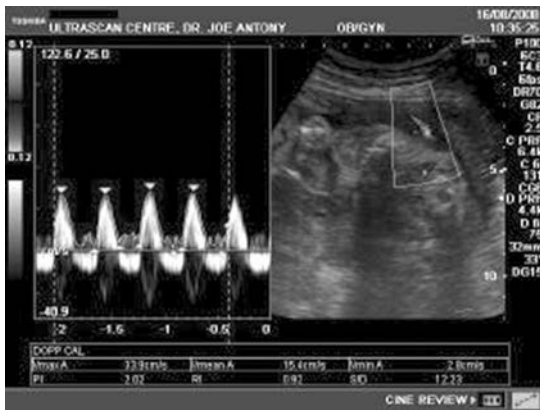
Doppler of umbilical artery showing reversed end diastolic flow
